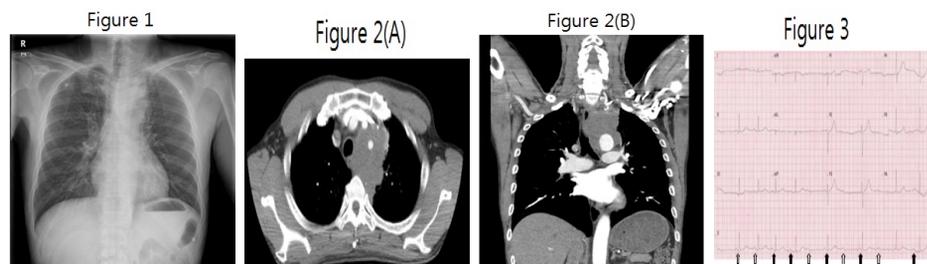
The chest x-ray demonstrated mediastinal widening with suspected soft tissue lesion at left apex (arrows).
